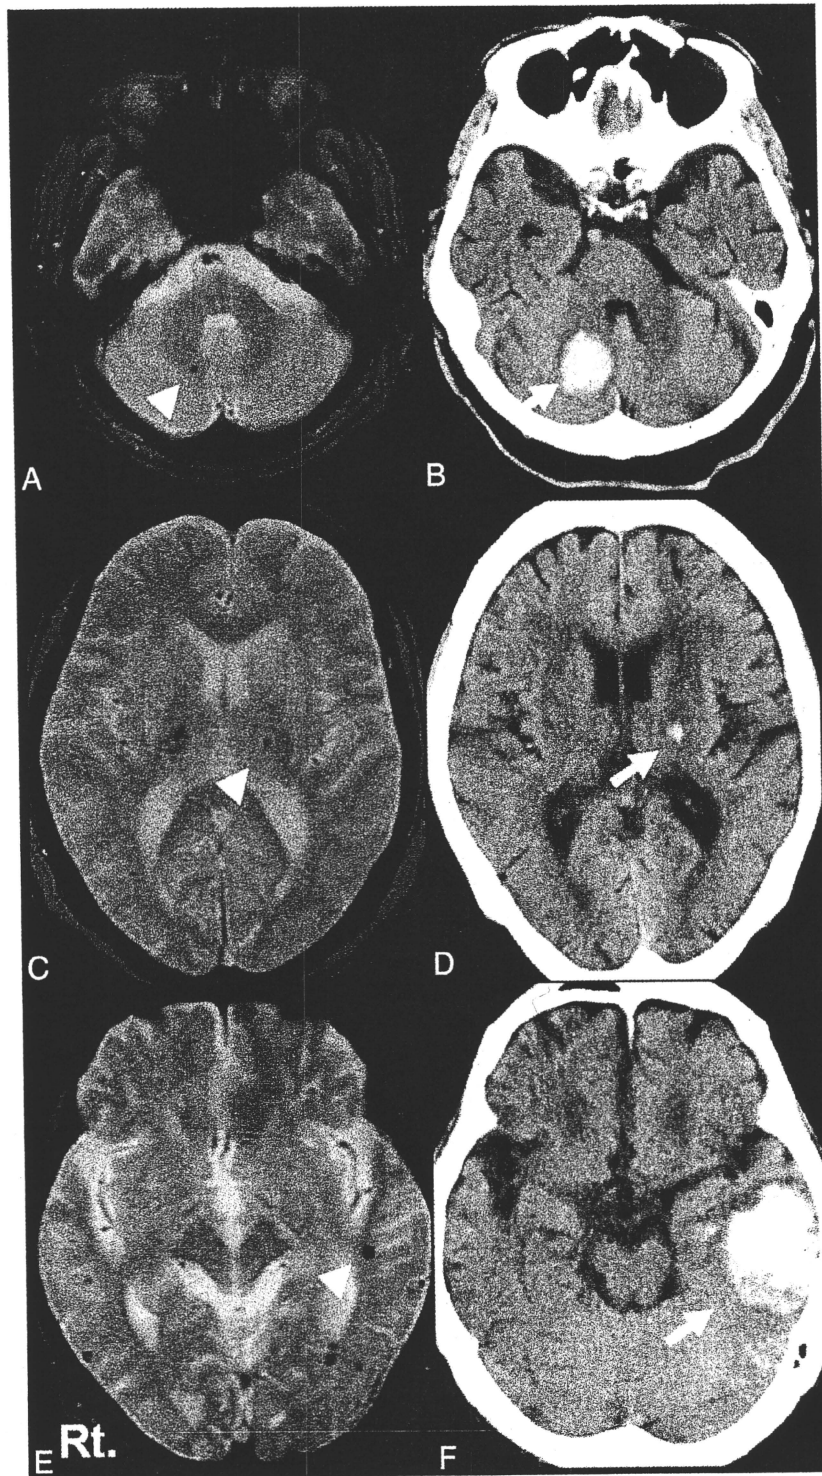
Representative cases. T2*-weighted MR image (A) and CT scan (B) in an 84-year-old patient. Recurrent right cerebellar hemorrhage (arrow) corresponds to the location of MBs detected 9 months before (arrowhead). T2*-weighted MR image (C) and CT scan (D) in an 80-year-old patient. Recurrent left thalamic hemorrhage (arrow) corresponds to the location of MBs detected 35 months before (arrowhead). T2*-weighted MR image (E) and CT scan (F) in an 85-year-old patient. Recurrent left lobar hemorrhage (arrow) corresponds to the location of MBs detected 3 months before (arrowhead).
